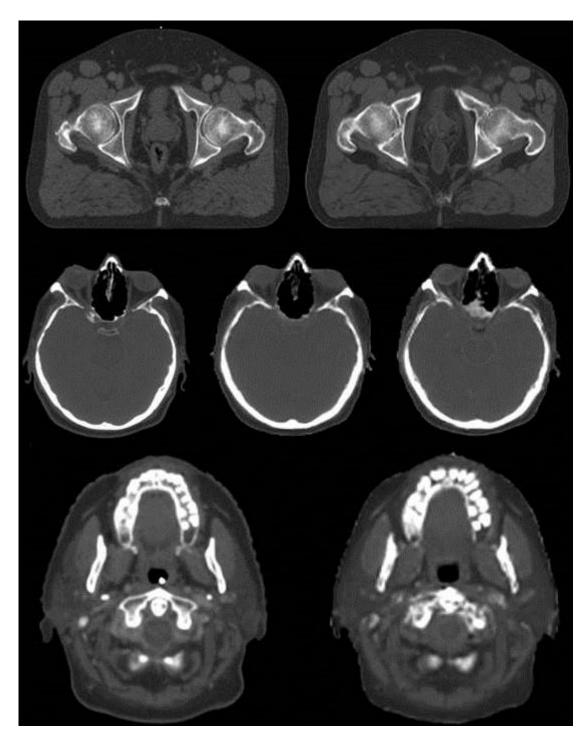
Axial slices of a pelvis CT and T2-SPACE sCT (top), brain cancer CT, T1Gd sCT and FLAIR sCT (middle) and H&N cancer CT and T1 sCT (bottom).
